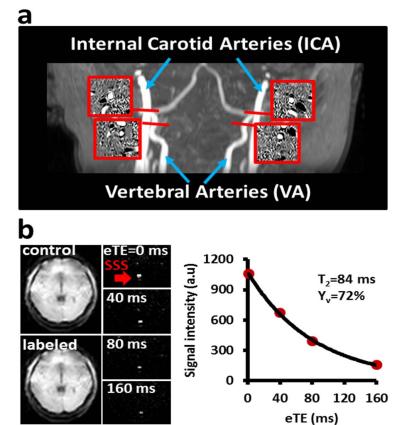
CMRO₂ technique. (a) Phase contrast MRI for the measurement of global CBF. (b) TRUST MRI for the measurement of global Y_v. Red arrow indicates the superior sagittal sinus (SSS).
